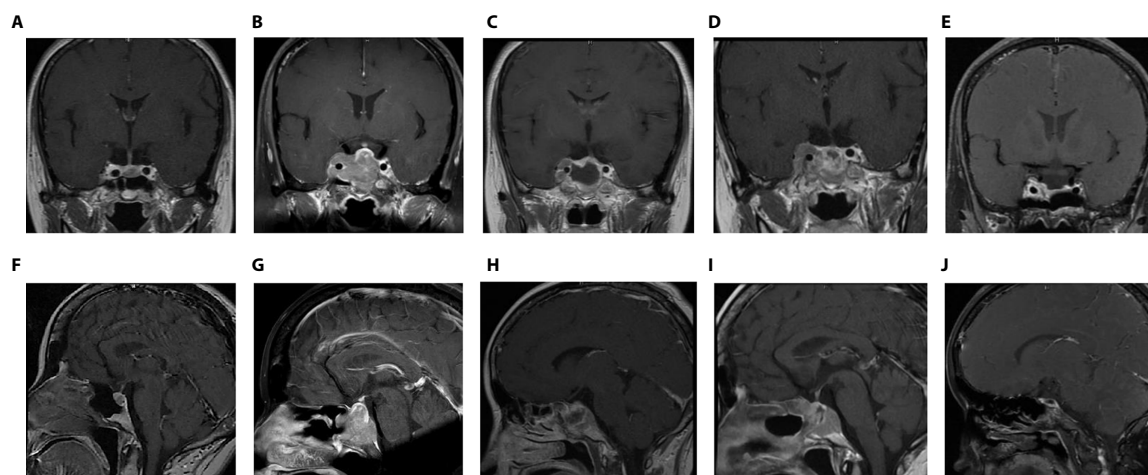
Coronal- and sagittal-enhanced MR images in various periods (A, B): Before the first operation (5 years after DA treatment); (C, D): 2 years after the first operation (before the second operation); (E, F): The day after the second operation; (G, H): 1 month after the second operation (the eve of TMZ treatment); (I, J): 6 months after TMZ treatment.
